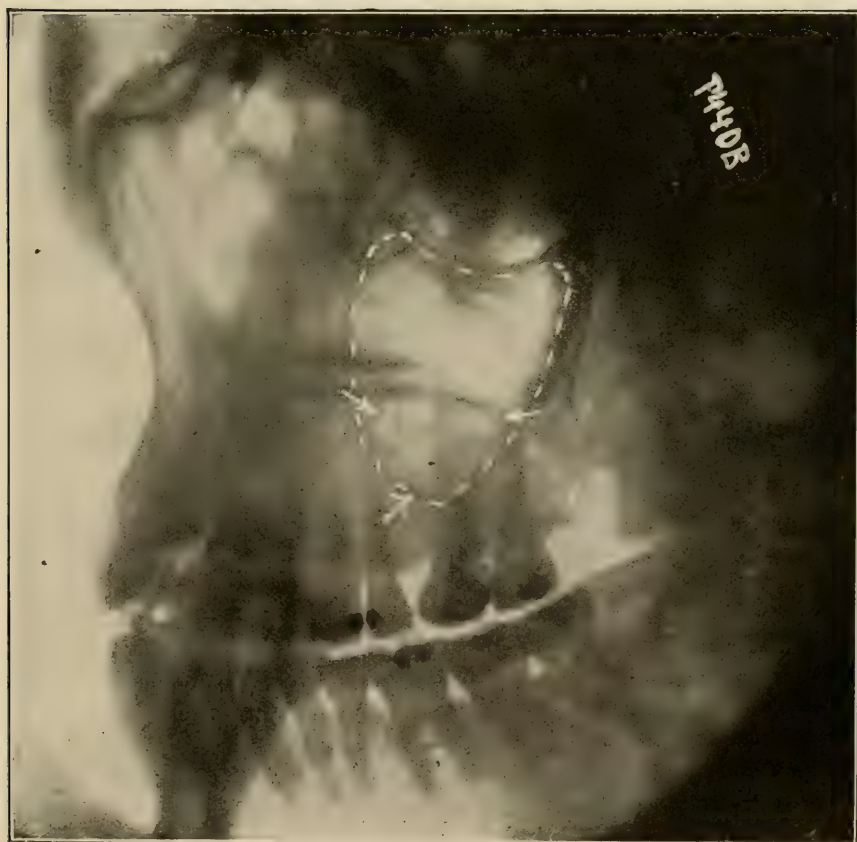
The dots outline a very large antrum. (Radiograph by Pfahler, of Philadelphia.)
